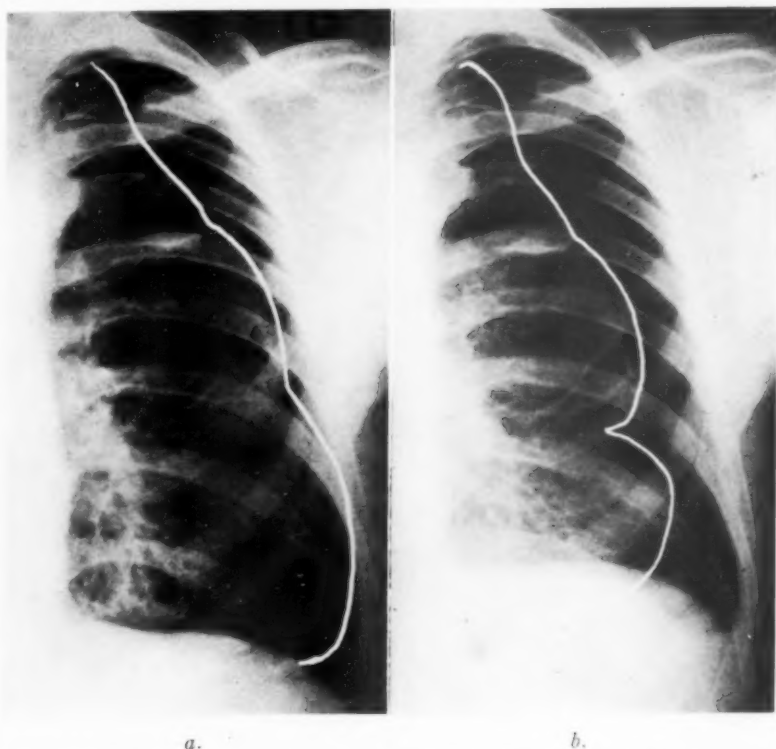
(a) deepest inspiration, (b) deepest expiration. These two roentgenograms show the marked difference in the *apparent* size of the pneumothorax cavity. The inspiration picture might wrongly suggest that the lower lobe is adherent to the chest wall.
